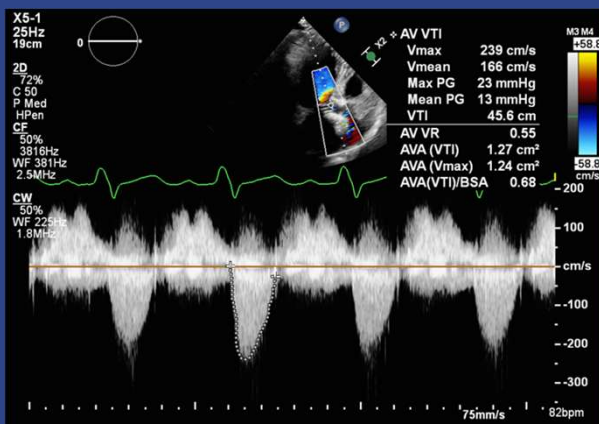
Apical CW Doppler across post-op day 1 TAVR, from author's clinical collection, di-identified (M.Trump, 2025)
